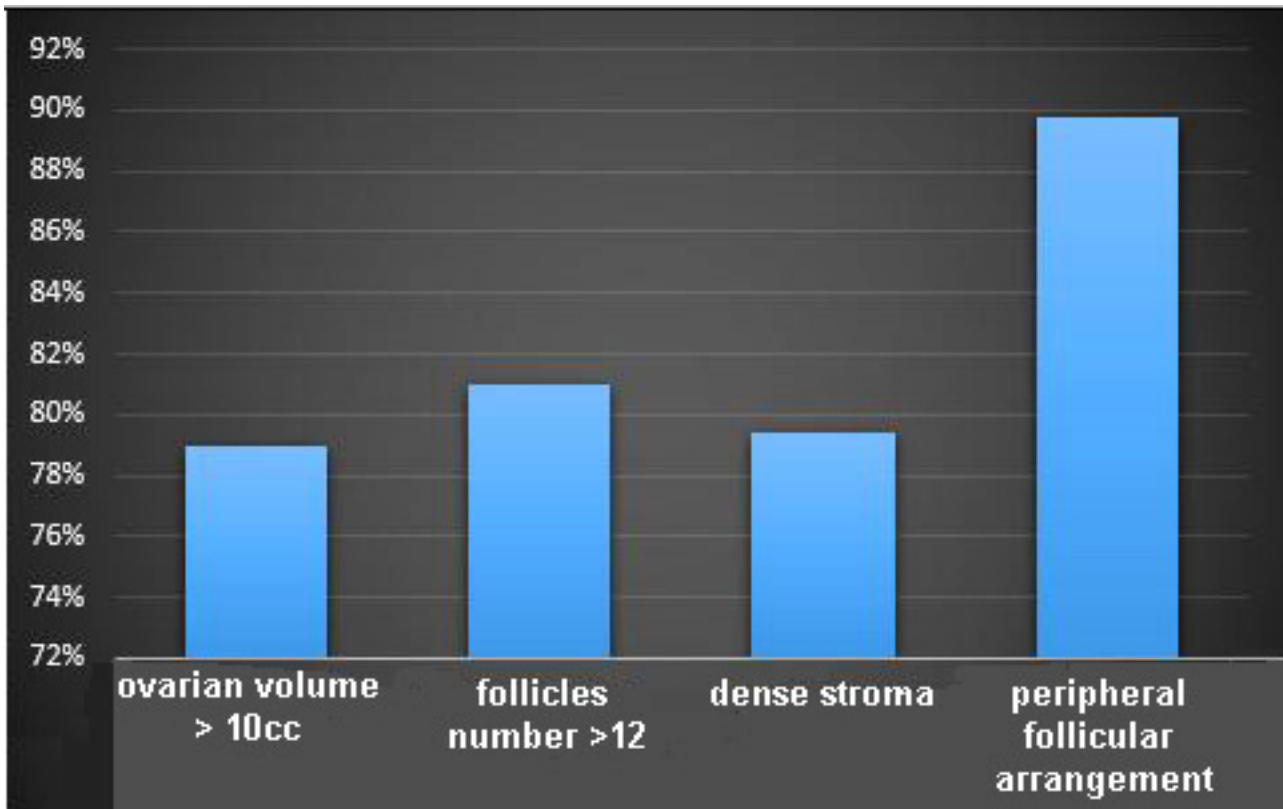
Distribution of sonographic features of PCO in left ovary.
